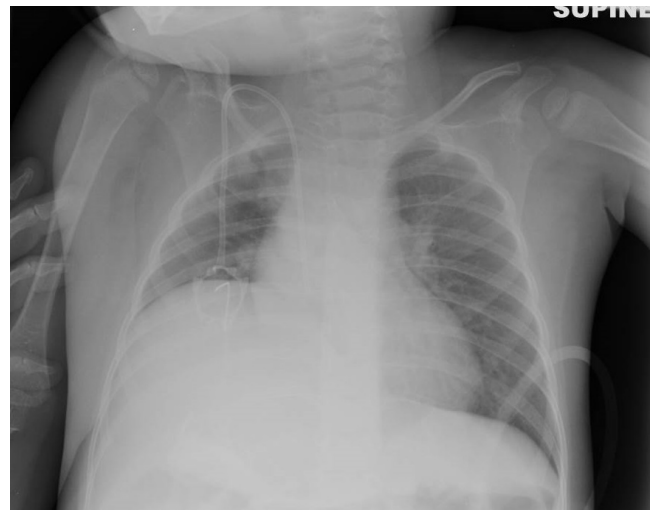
Chest radiograph showing elevation of the right hemidiaphragm, which is a concern for a phrenic nerve injury.
